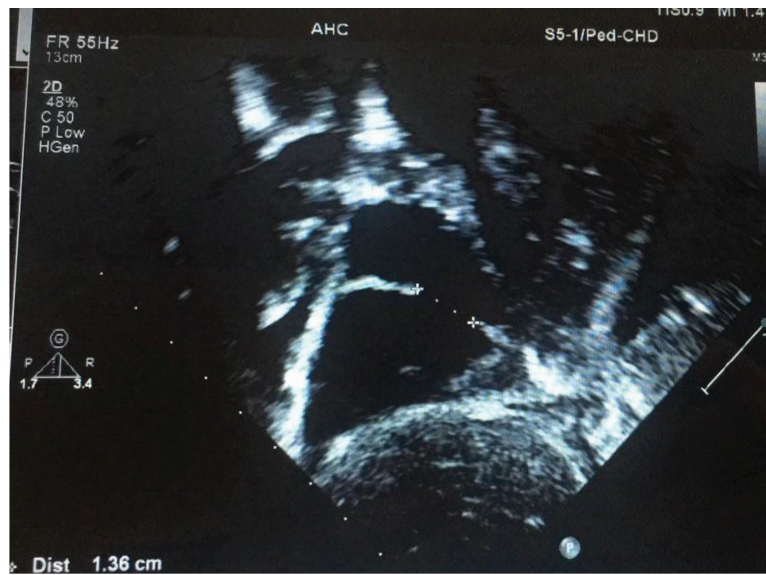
Echocardiography: Large atrial septal defect (ASD).
